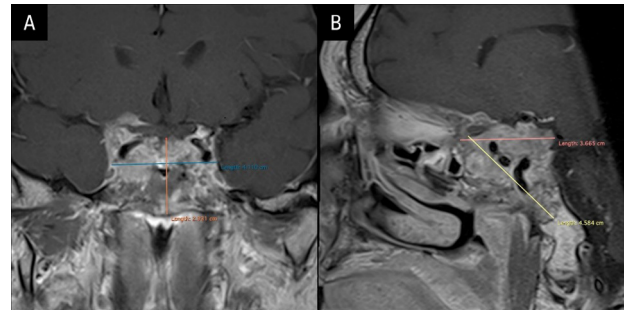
Magnetic resonance imaging (MRI) after 3 cycles of temozolomide treatment — 08.10.2021. A. Cranio-caudal (CC) plane; B. Sagittal (Sag) plane
